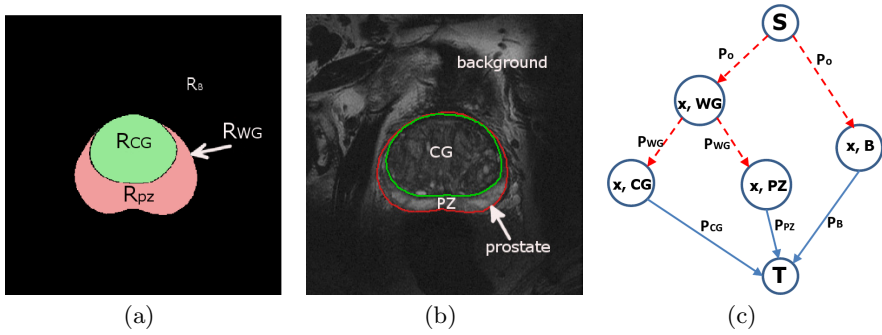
Proposed layout of anatomically consistent regions (a) and contours overlaid on a T2w prostate MRI slice (b). The prostate region \mathcal{R}_B is divided into two sub-regions: central gland \mathcal{R}_{CG} and peripheral zone \mathcal{R}_{PZ} and is mutually distinct from the background \mathcal{R}_B . (c) shows the proposed spatially continuous flow-maximization scheme.
